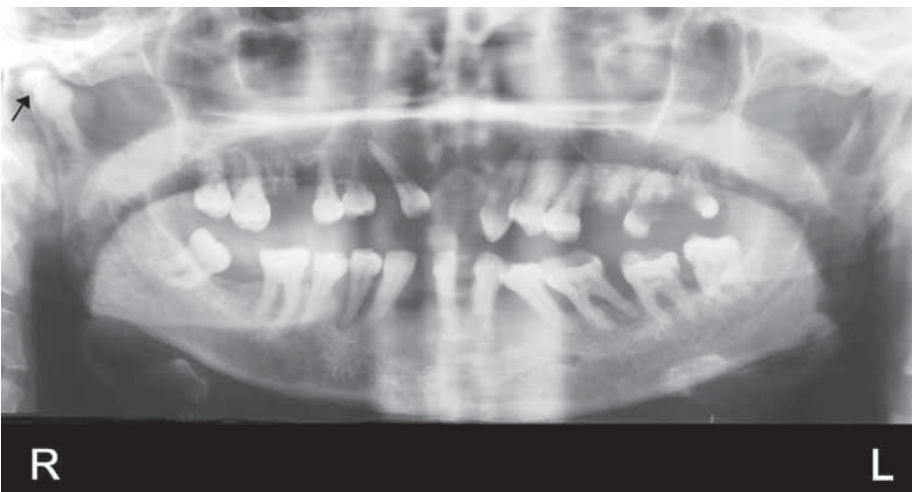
Case 2: Panoramic radiograph showing a bifid right mandibular condyle (see arrow).
